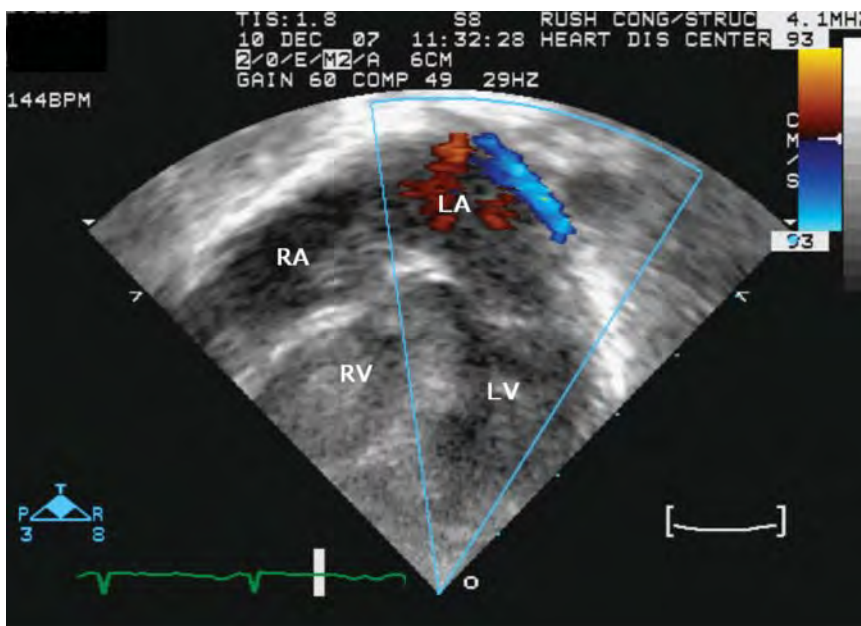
Apical four-chamber view demonstrating a small tricuspid valve with hypertensive thickened right ventricle (RV) and bowing of the interventricular septum into the left ventricle (LV). LA, left atrium; RA, right atrium.
